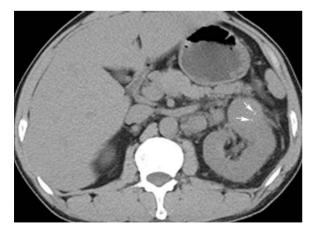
Collecting duct carcinoma in a 38-year-old woman. Axial unenhanced CT scan reveals multiple tiny calcifications (*arrows*) within the exophytic tumor in the left kidney.
